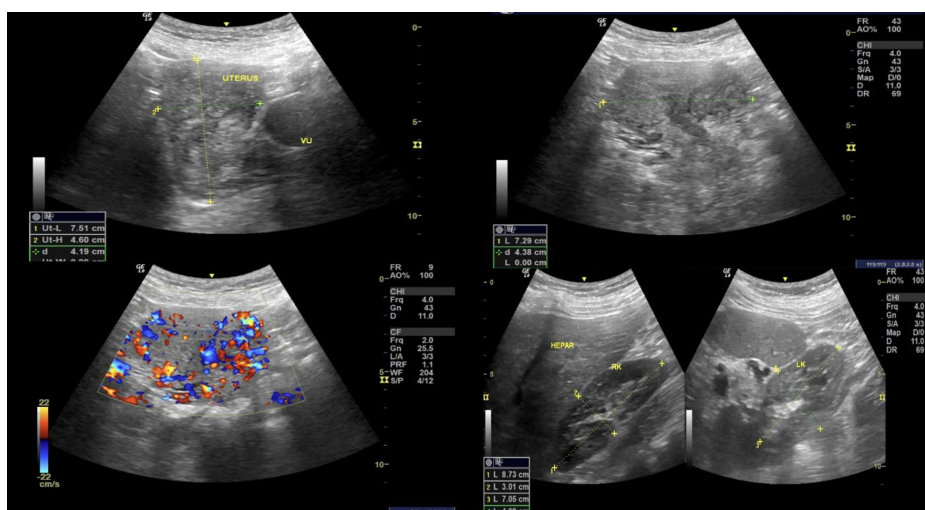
Gynecologic Ultrasound
